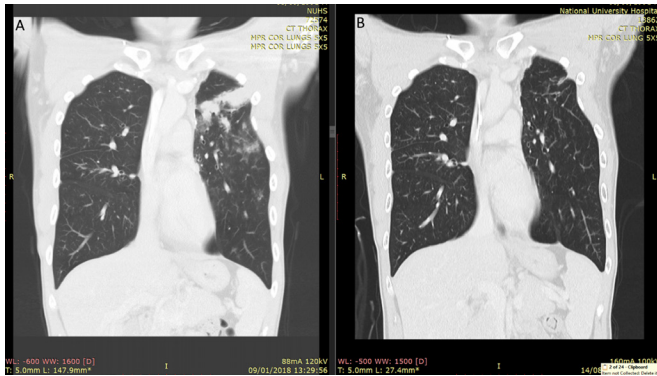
High-resolution chest CT scan (A) 10 months before compassionate treatment; (B) 269 days after no treatment.
